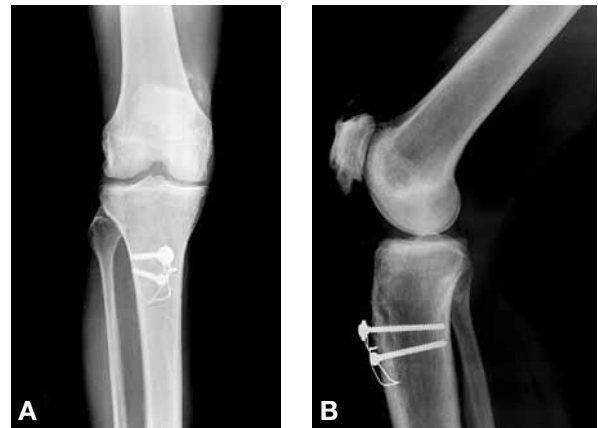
(A) Anteroposterior, (B) lateral, and (C) sunrise radiographs 32 months after surgery show maintenance of normal patellar height and mild patellofemoral osteoarthritic changes.
